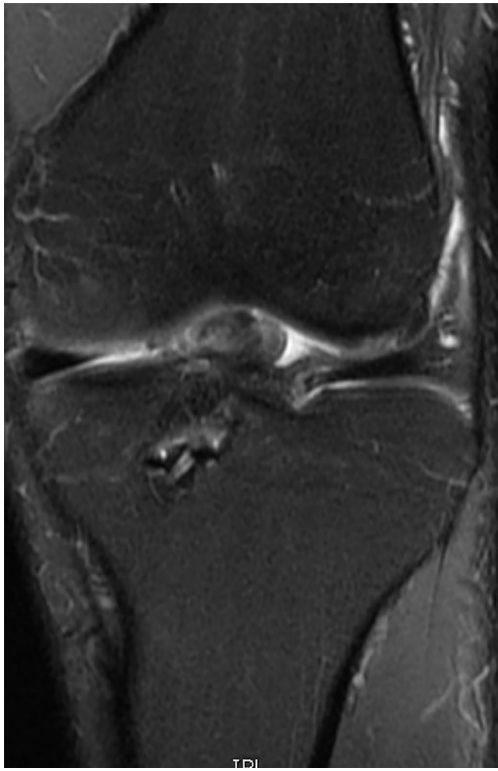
MRI demonstrating graft with impingement. MRI, magnetic resonance imaging.
